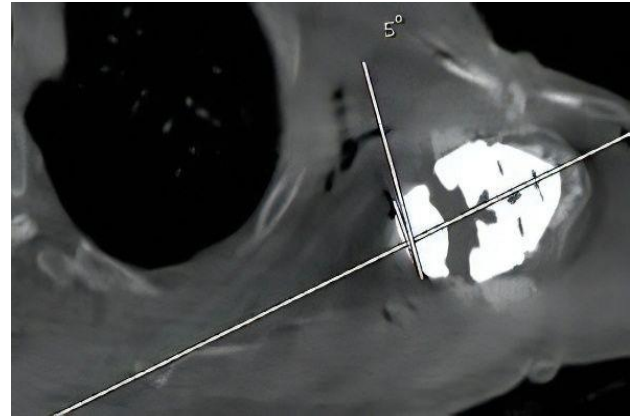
Post-operative 2D mid-axial CT cut showing glenoid version measurement (between the two vertical white lines).
